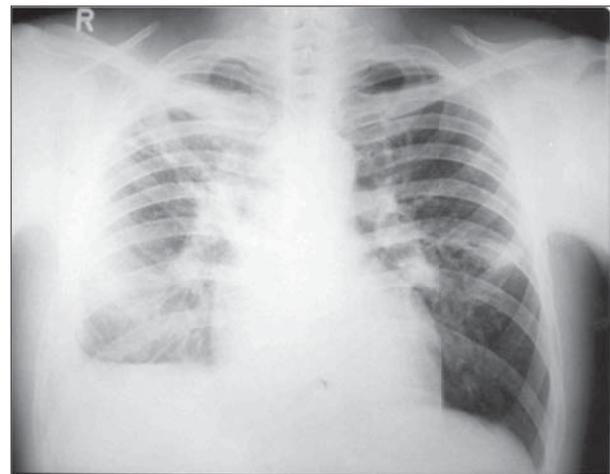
Posteroanterior chest radiography on admission: enlarged heart and hilar shadows, diffuse pulmonary parenchymal opacities, partially excavated, especially expressed in the right infraclavicular and left perihilar fields with bilateral obliteration of costophrenic sinus
